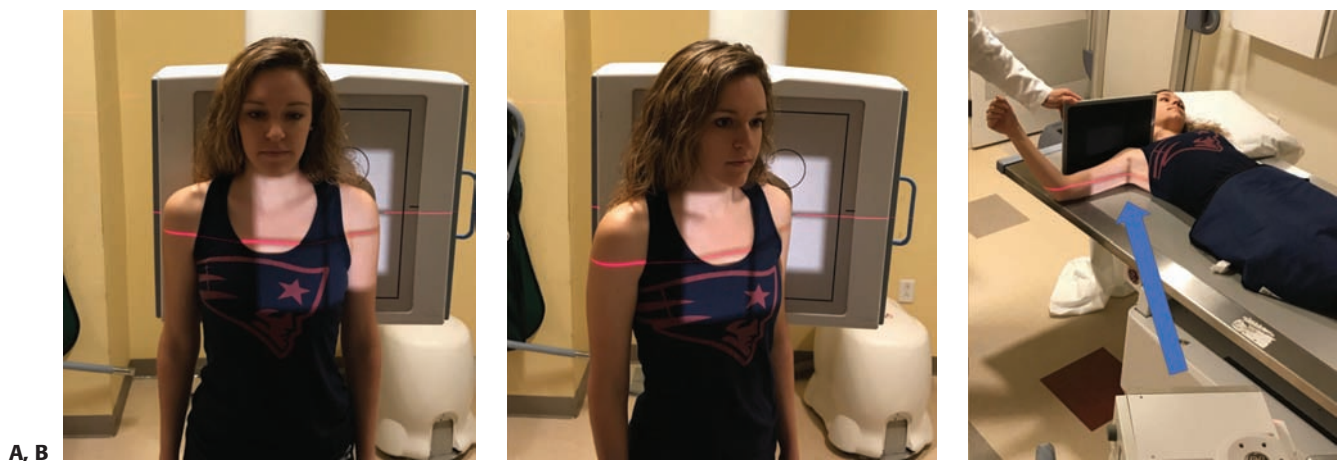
A: Anteroposterior radiographic view is performed with the beam aligned to the body. B: Grashey view is done with the beam centered with the glenohumeral joint line. C: Axillary view is done with the arm in abduction and the plate is placed behind the patient’s shoulder in the supine position. The radiographic beam is aimed 45 degrees to the axilla.
